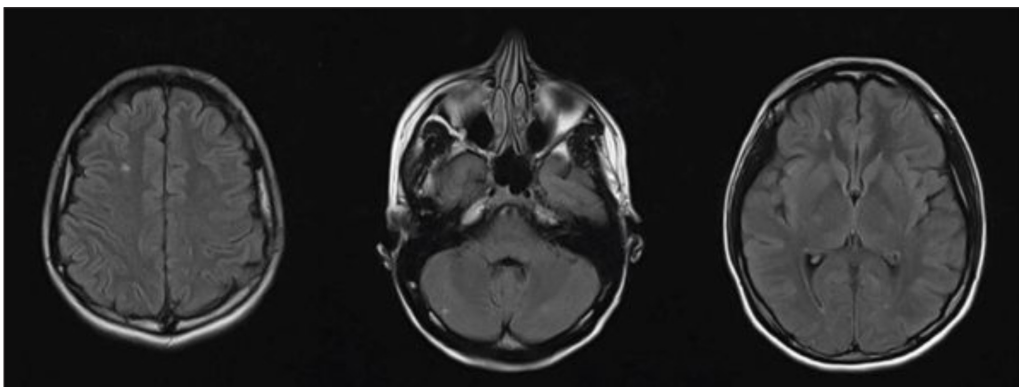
T2 weighted MRI axial sequences demonstrating multiple supra- and infra-tentorial hyperintensities in the right cerebral and cerebellar hemispheres.
